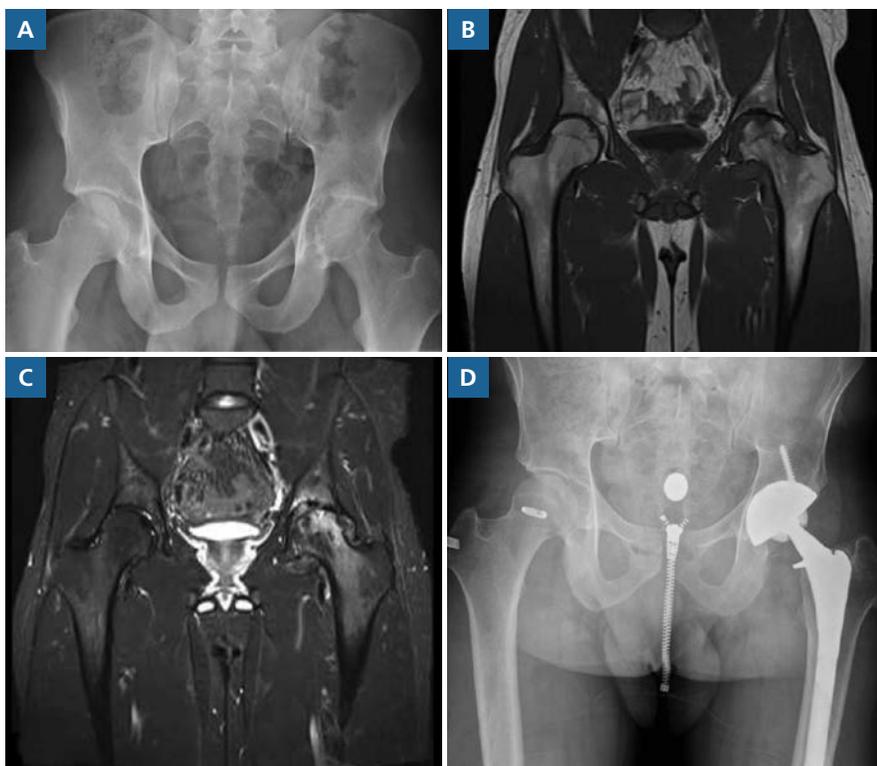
Anteroposterior (AP) radiograph of the pelvis in a 22-year-old male demonstrates advanced joint-space narrowing and cortical erosions in the femoral head and acetabulum of the left hip (A). Magnetic resonance imaging reveals characteristic synovial process with low signal intensity in both T1- and T2-weighted sequences (B and C, respectively). This patient underwent total hip arthroplasty (D).
